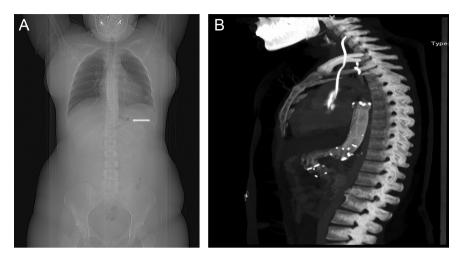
(a) X-ray view of the 2 stents placed in telescopic fashion, arrow indicates the junction of 2 stents. (b) Stents in CT images, sagittal reconstruction.
